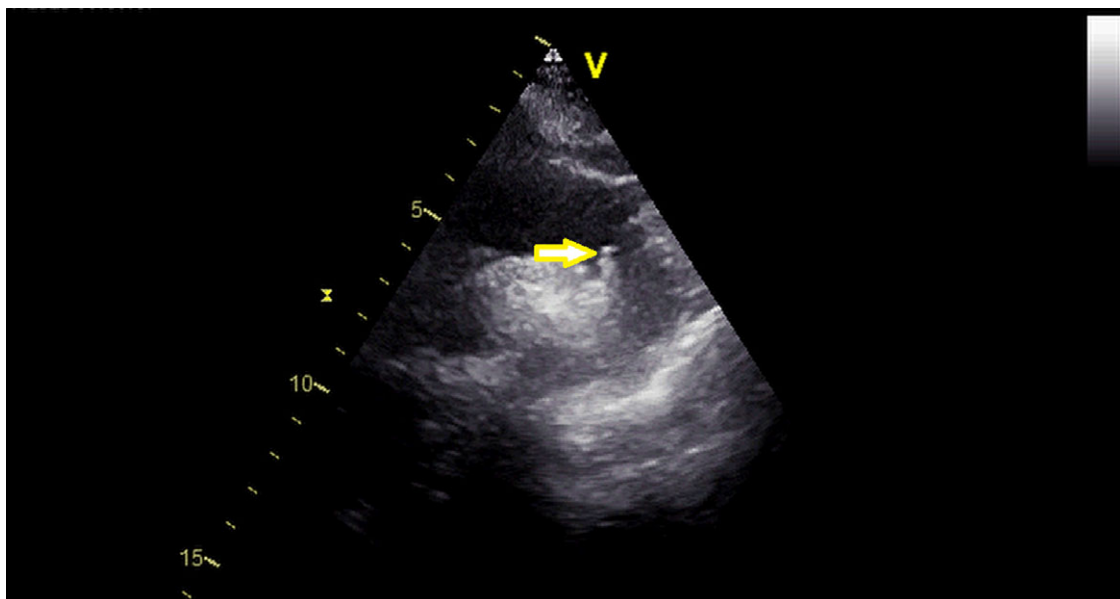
Thrombus in the aortic stent (on the echocardiography).
